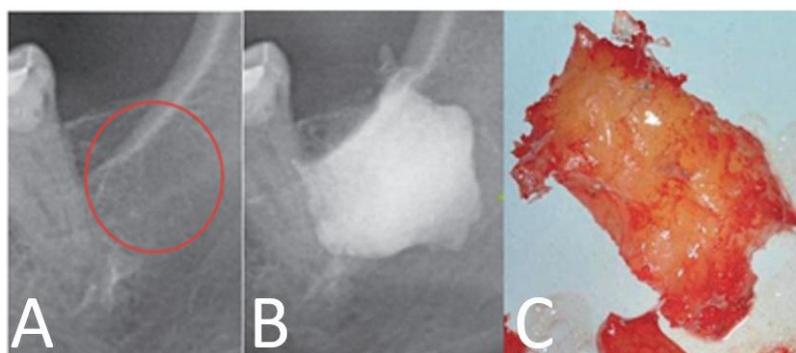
Radiographic inconspicuous FDOJ affected area(A,C) made visible with contrast agent(B) [Ref.:Lechner et al., 2018].
